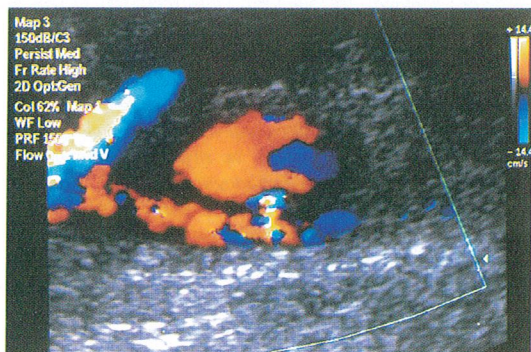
A pseudoaneurysm originating from the deep femoral artery is seen in the color Doppler examination.
